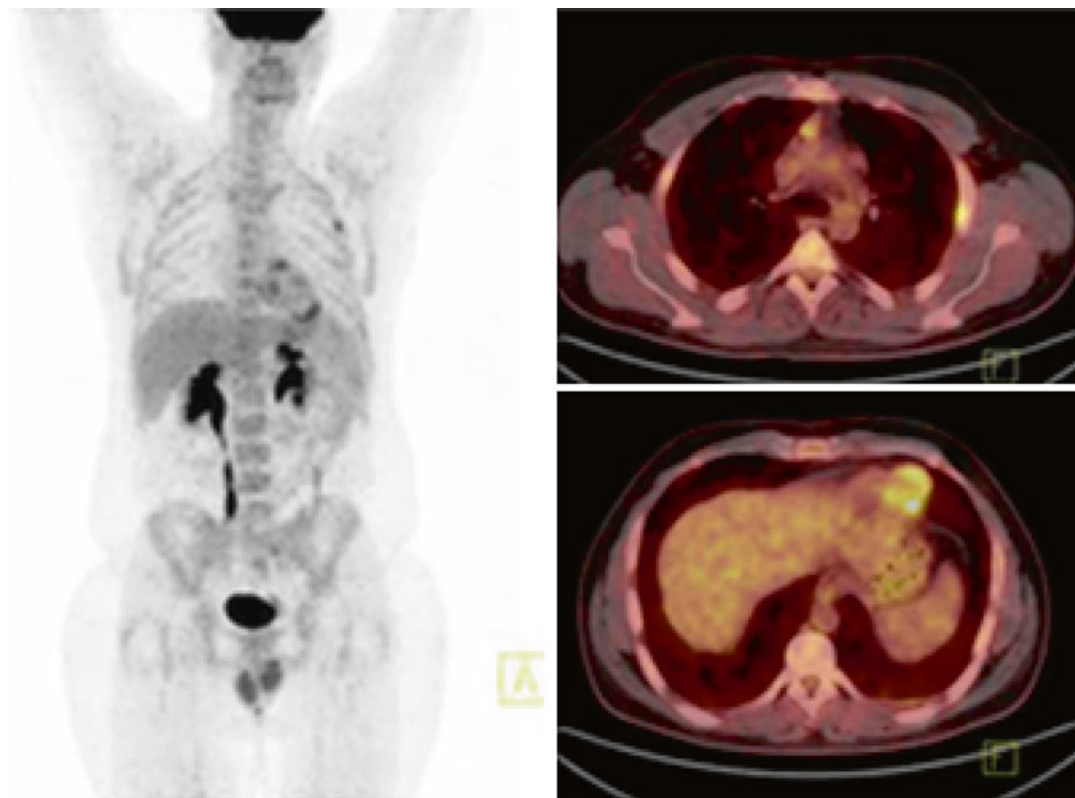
PET/CT post one cycle of BEACOPP-escalated: residual node at the upper mediastinum (D5-PS score 4) and focal increase in FDG uptake at the left 3rd rib
